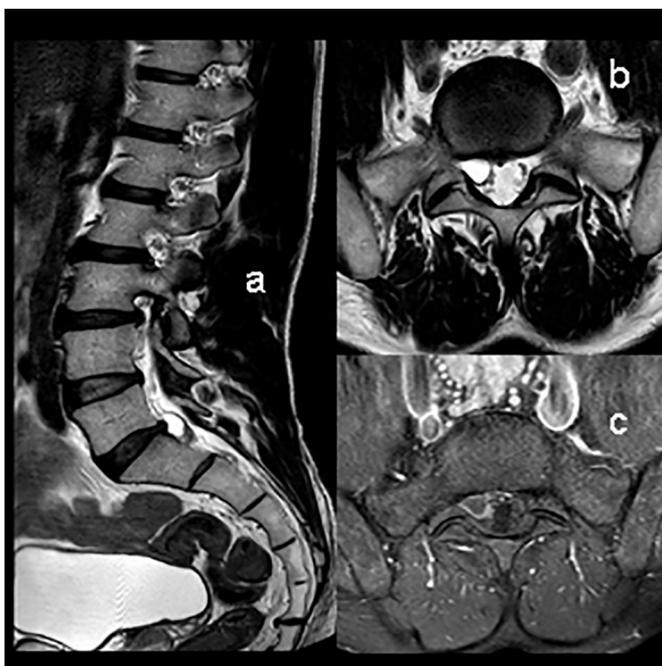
T2W sagittal and axial (a,b) and post-contrast T1W (c) MRI.
